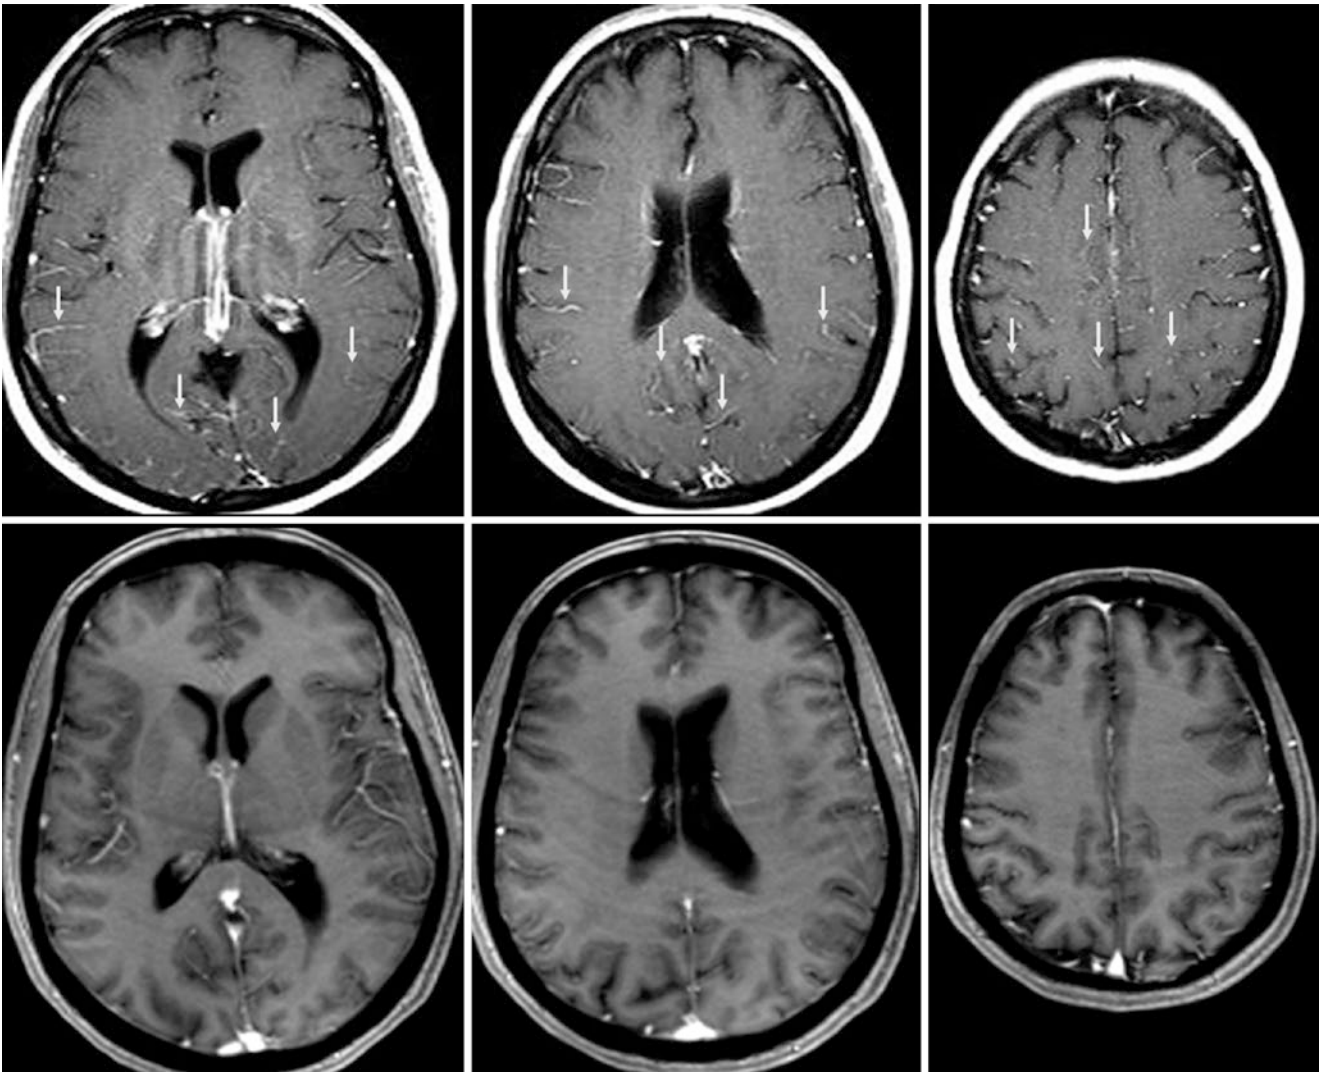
A 40 year old with cranial nerve XII symptoms had a negative 3T MRI (without sedation) that showed slight pseudo-LMCE (arrows) on CE SET1WIs (*top row*), which disappeared on CE GET1WIs (*bottom row*). This demonstrates how there can be subtle differences in the degree of vascular or leptomeningeal enhancement between sequences
